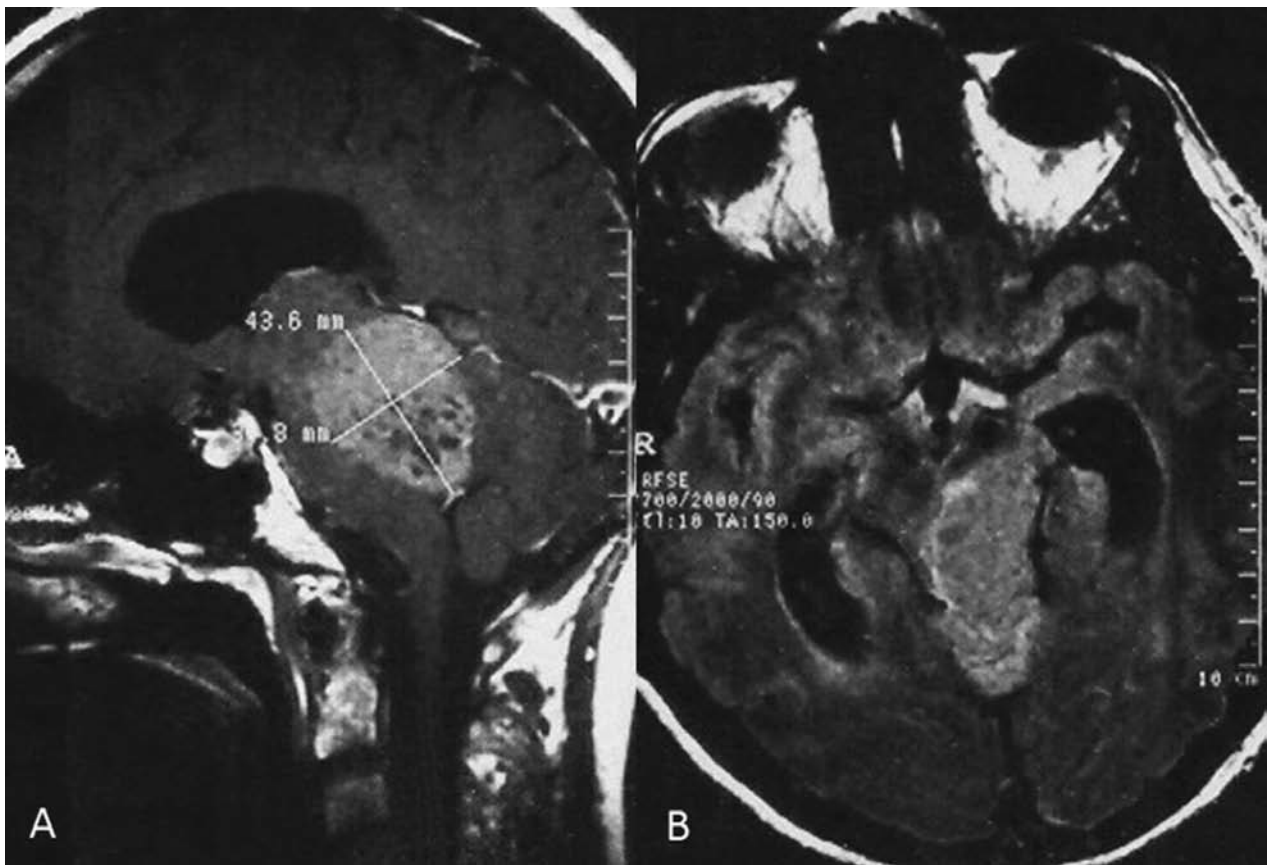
Pre-operative MRI, sagittal (A) + axial (B) scan, tumor located in the 4th ventricle and invading the brain-stem
